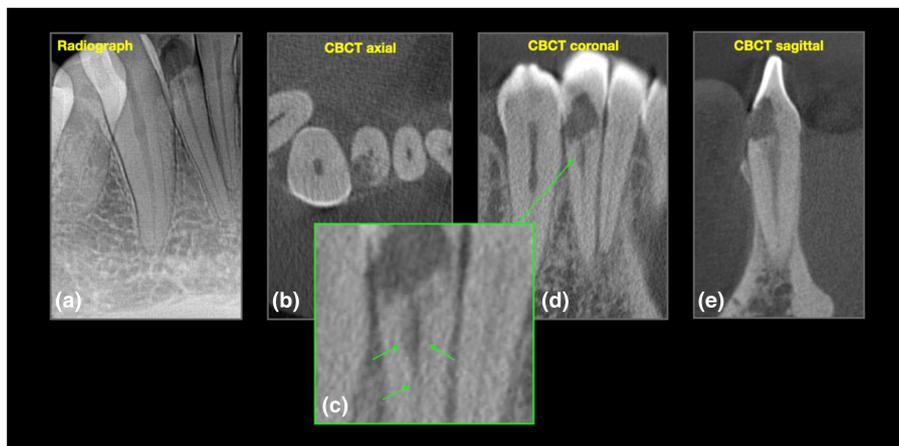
External cervical resorption (ECR; Patel 2Bp). (a) Radiograph reveals a well-defined radiolucency (resorptive/destructive phase) in the coronal aspect of the tooth, (b–e) Cone beam computed tomography reveals the ECR spreads (b) up to 180° around the tooth, (c–e) extends into the coronal-third of the root, as highlighted by the green arrows.
